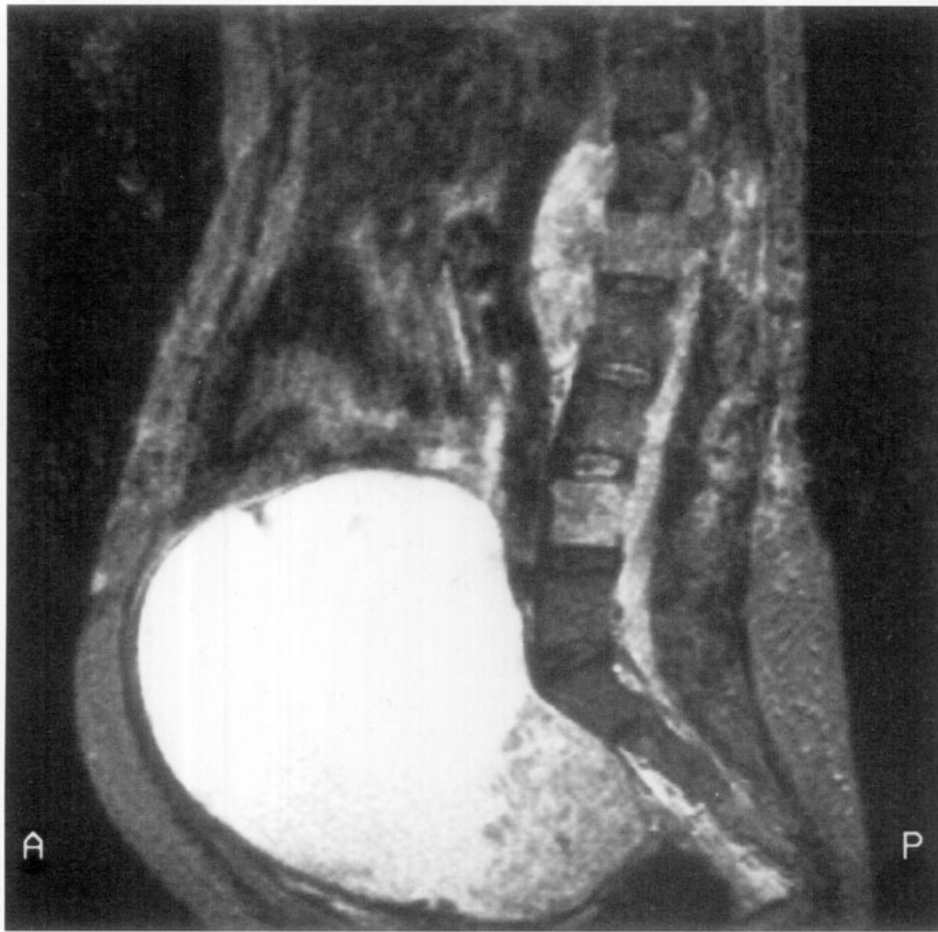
Both the spinal metastases and the primary tumor are inhomogeneous on the T2-weighted SE sequence (TR 2760; TE 100). The primary tumor is largely cystic.
